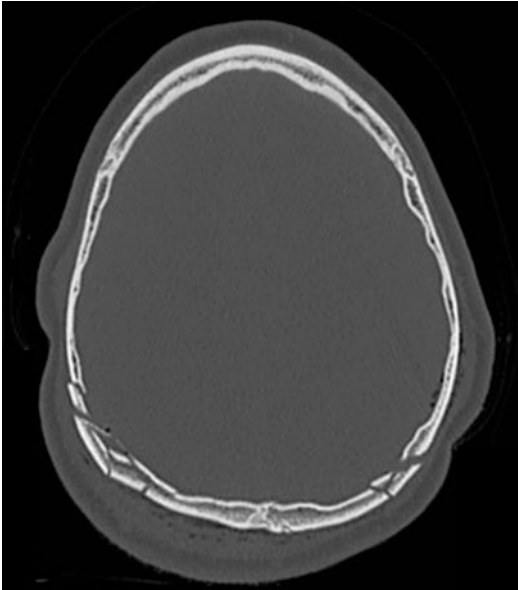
Axial CT with bone reformatting to reveal extensive calvarial fractures of the parieto-occipital region
